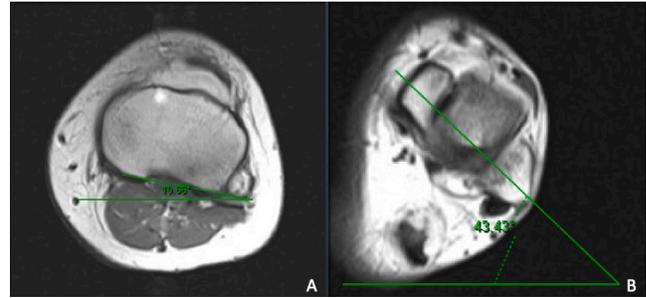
Depiction of tibial torsion of the right lower extremity on preoperative magnetic resonance image (MRI), which demonstrate the angles between lines connecting the posterior tibial condyles (A) and center of the medial and lateral malleolus (B) relative to the horizontal axis, totaling 54.09 degrees.
